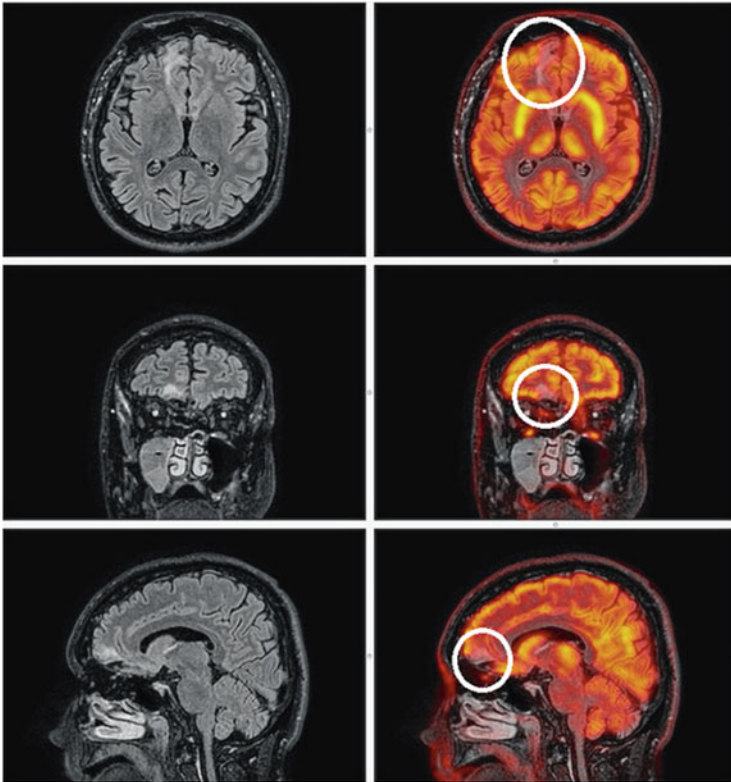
Integration of PET and MRI images—alteration in frontal lobe
